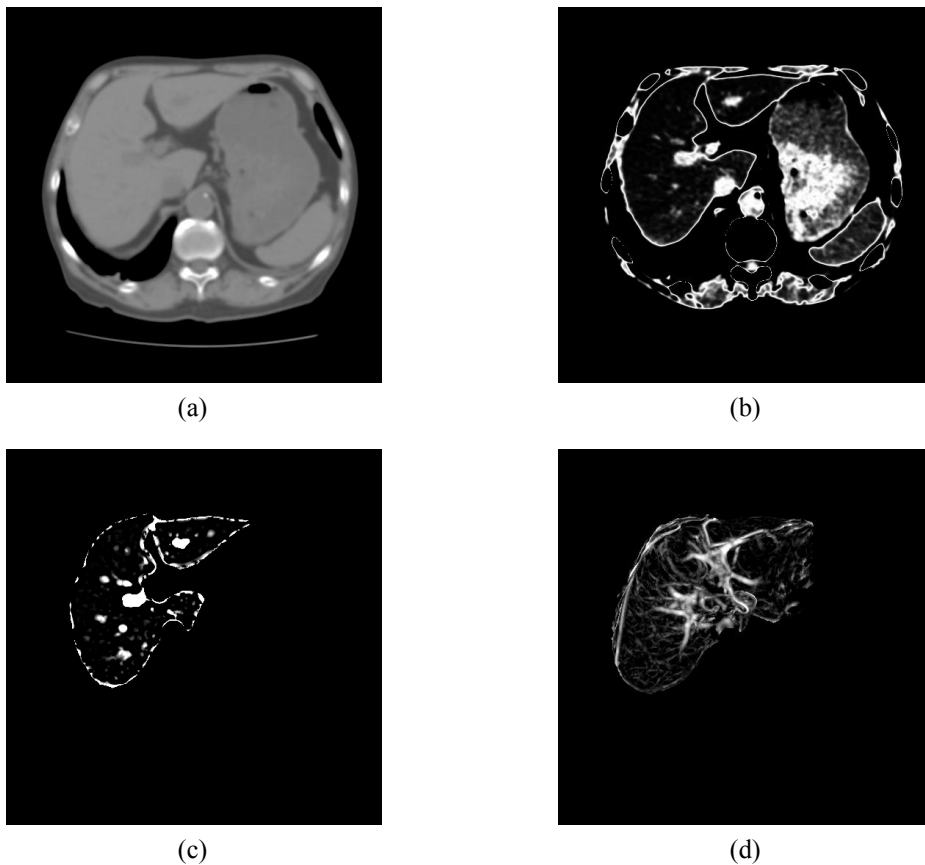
Enhancement of hepatic vessels. (a) A result of noise reduced input CT image using Gaussian filter, (b) enhanced (a) image using Gaussian window function, (c) enhanced (b) image using line enhancement filter (inside liver region), and (d) MIP image of (c) (axial direction).
